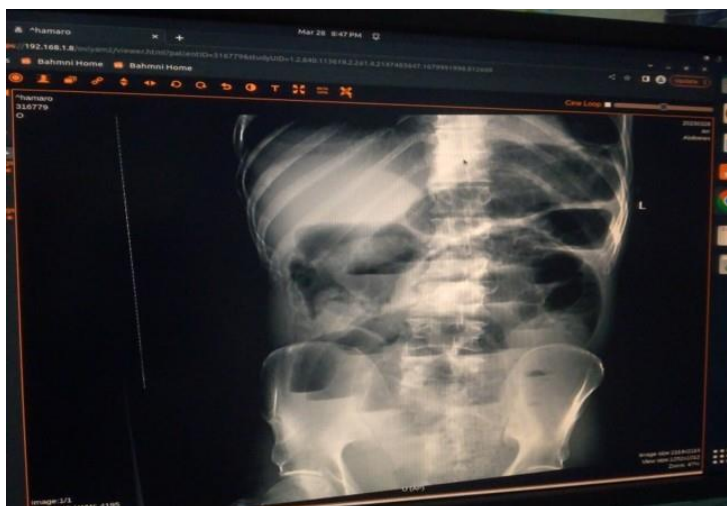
Erect abdominal x-ray with dilated small bowel loops and multiple air-fluid levels.
